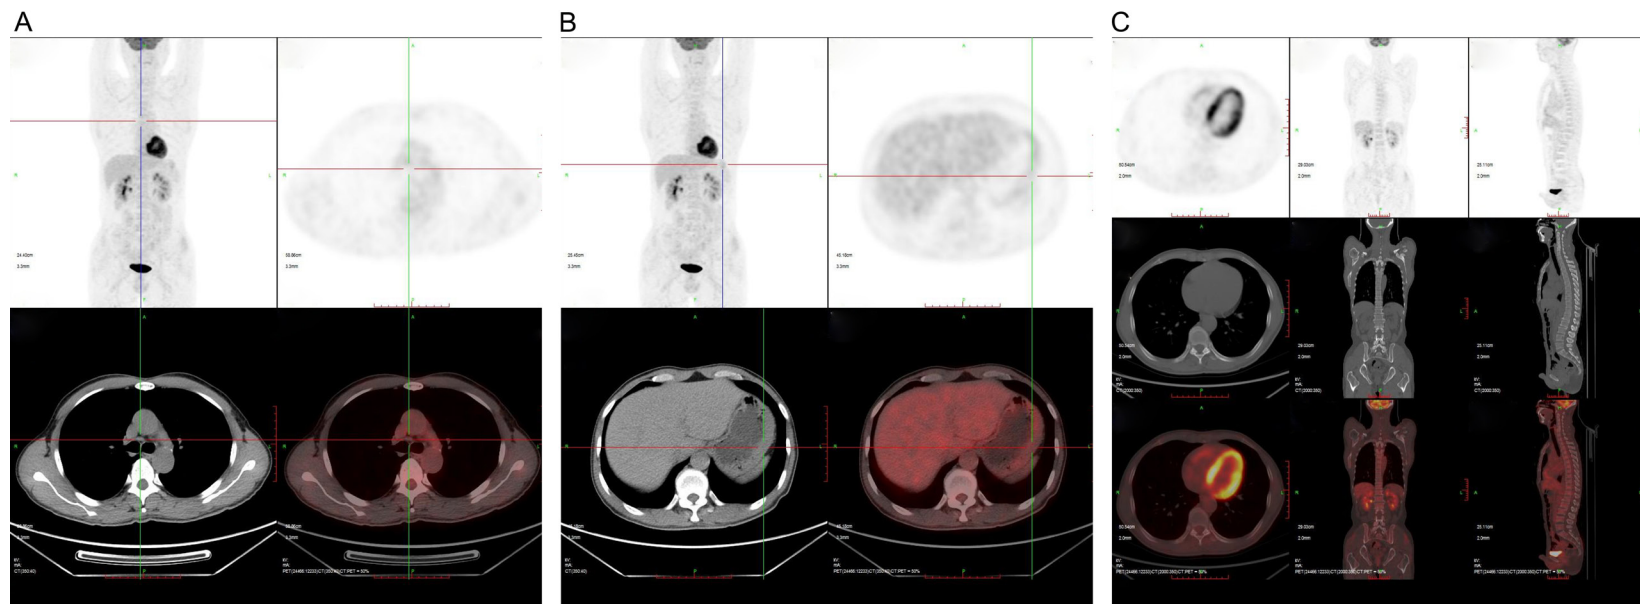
PET-CT images of this patient. (A) The patient had no hepatosplenomegaly in PET-CT. (B) No enlarged lymph nodes were seen in this patient. (C) The patient had no osteosclerotic lesions as well.
